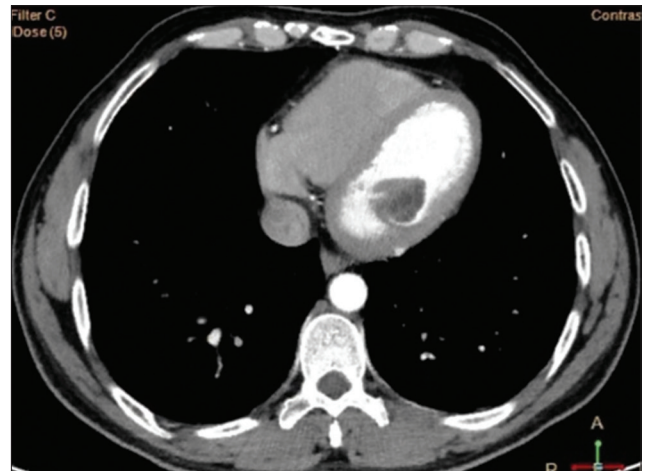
Cardiac hydatid cyst (computed tomography scan with contrast, axial cut)
